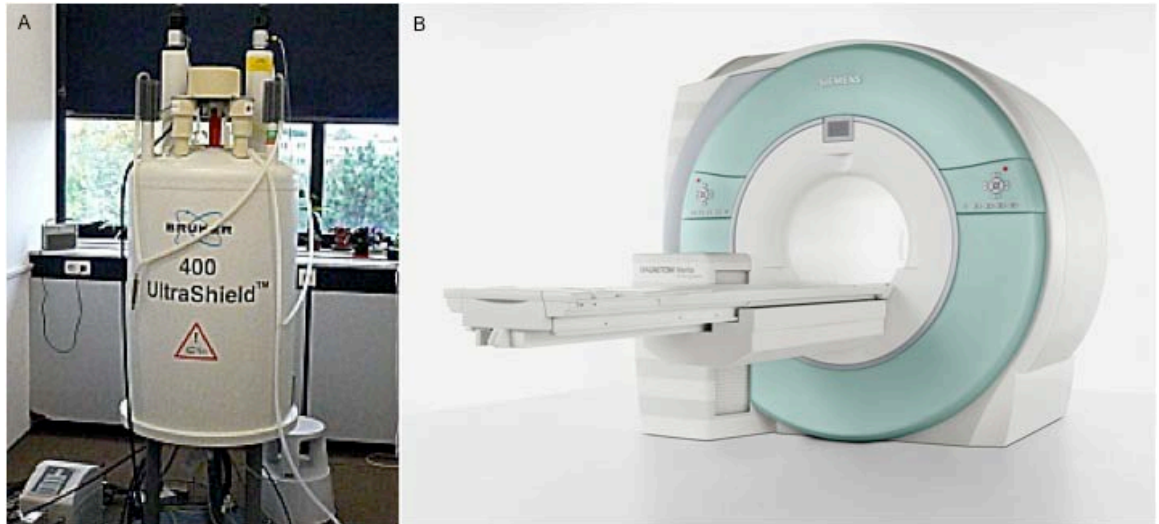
Photos of MRI scanners used in this project. A) Bruker Avance II laboratory 9.4 Tesla MRI scanner in the School of Physics, University of Leeds. B) Siemens Magnetom Verio 3 Tesla scanner in the Leeds Musculoskeletal Biomedical Research Unit, Chapel Allerton Hospital, Leeds.
